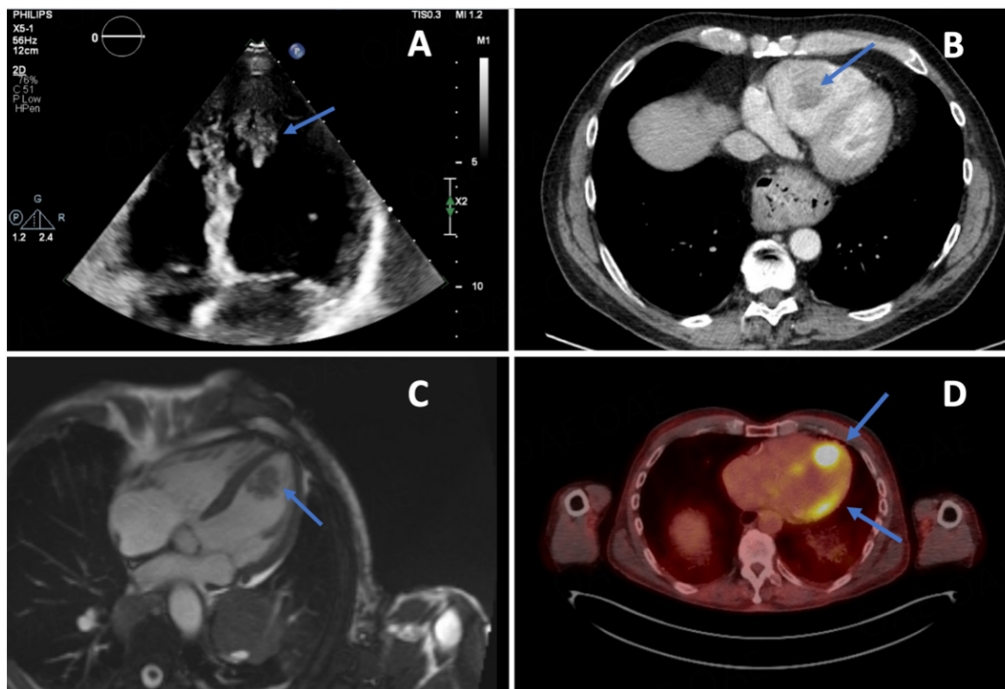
Multiple imaging modalities have been used to detect suspected cardiac melanoma. (A) Echocardiogram showing a 3.1 cm × 2.4 cm mobile echodensity at the apex of the left ventricle concerning for thrombus or tumor. (B) Chest CT showing a 4.3 cm mass in the right ventricle consistent with malignancy. (C) Cardiac T2-weighted MRI displaying a mixed tumor and thrombus at the apex of the left ventricle. (D) PET scan of a hypermetabolic mass at the apex of the left ventricle.
